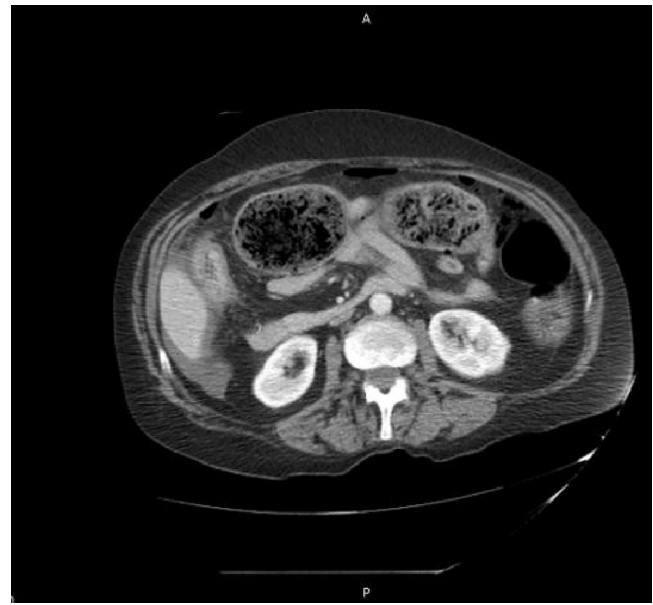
Preoperative axial CT Abdomen showing small pockets of free gas at the anterior abdominal wall, colonic perforation and fecal impaction of the large bowel.
